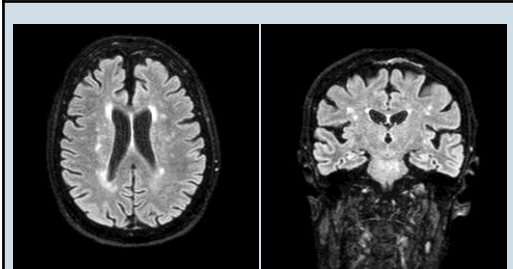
Brain MRI FLAIR sequences, axial and coronal sections
